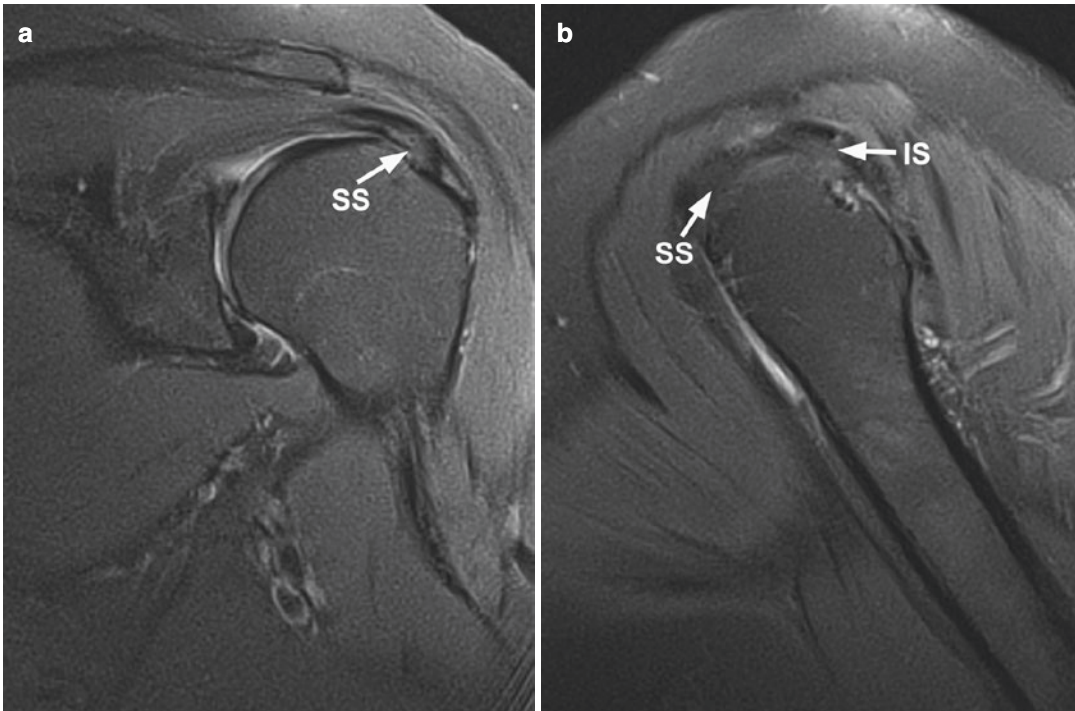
Rotator cuff tendinosis. Coronal (a) and sagittal (b) oblique T2-weighted (T2W) fast spin echo (FSE) images with fat suppression (fs) show intermediate signal
